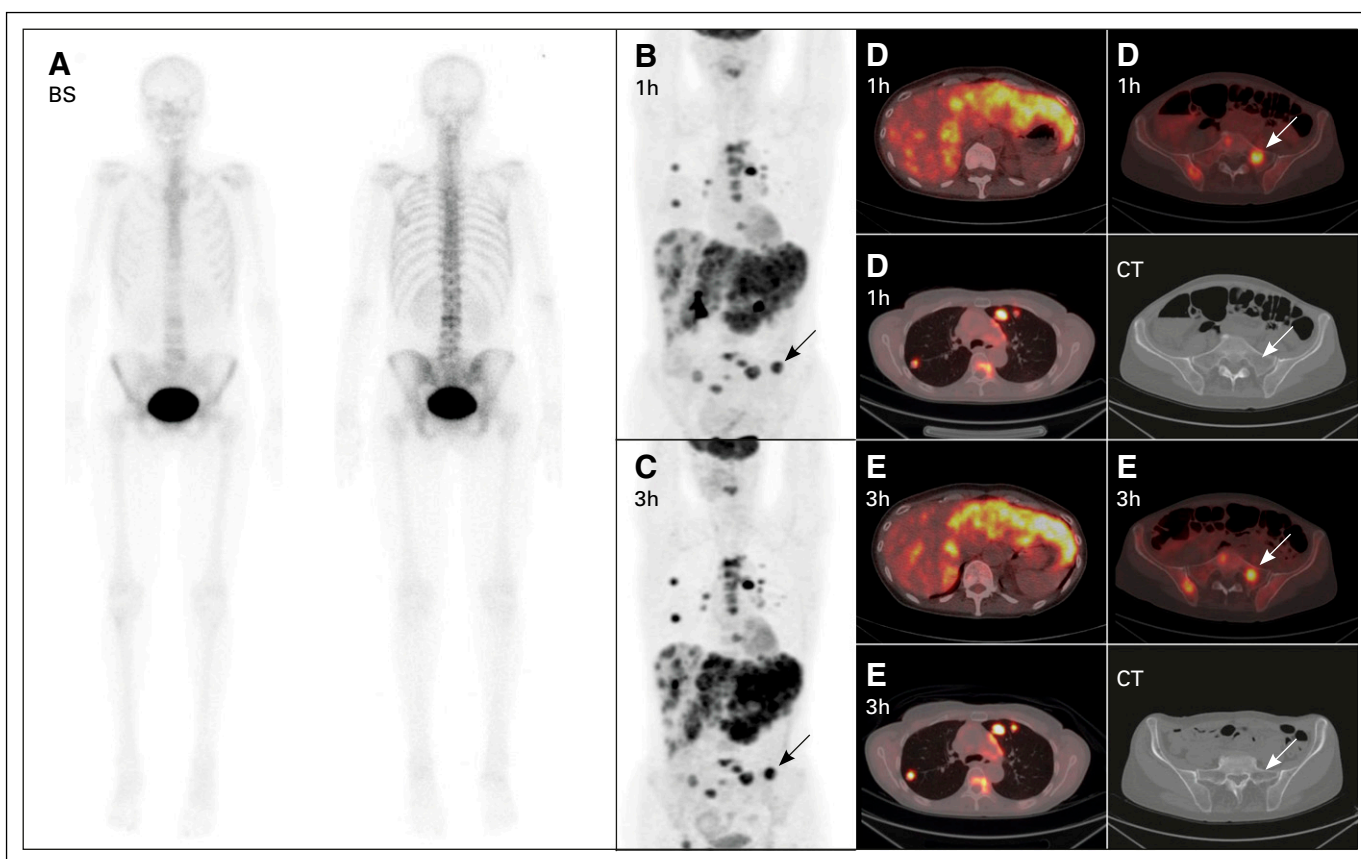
Example of a patient with multiple metastases, including bone, as visualized by the three modalities. Little is seen on the bone scintigraphy (BS), whereas several [^{18}F]fluorodeoxyglucose (FDG)-avid lesions are shown on FDG-positron emission tomography (PET)/computed tomography (CT). An example of this is the lesion on the right side of the sacrum (arrow). The CT scan did not detect this lesion. Notice also the difference between the 1-hour (1h) and 3-hour (3h) scans. For clinical interpretation, we hardly noticed a difference. With regard to the imaging quality, the delayed image showed higher uptake in the lesions and lower uptake in background tissue. This issue may be important in a clinical situation with the differentiation between limited or nonrecurrent disease. (A) BS in anterior and posterior projection. Maximum intensity projection images of FDG-PET/CT at (B) 1 hour after FDG injection (1h) and (C) 3 hours after FDG injection (3h). Transaxial images at (D) 1 hour after injection and (E) 3 hours after injection, and low-dose CT scans showing lesions in the liver, lung, and bone (arrow).
